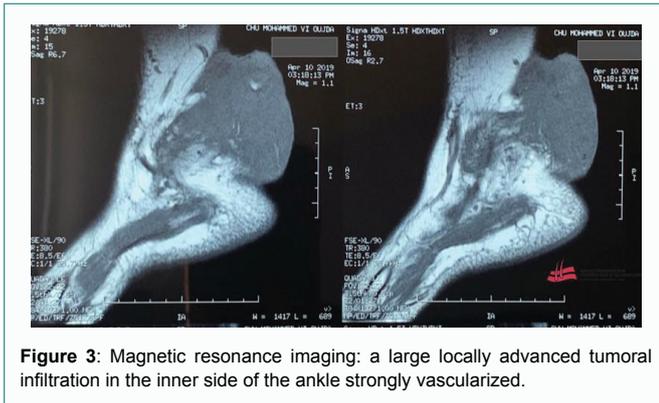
Magnetic resonance imaging: a large locally advanced tumoral infiltration in the inner side of the ankle strongly vascularized.
